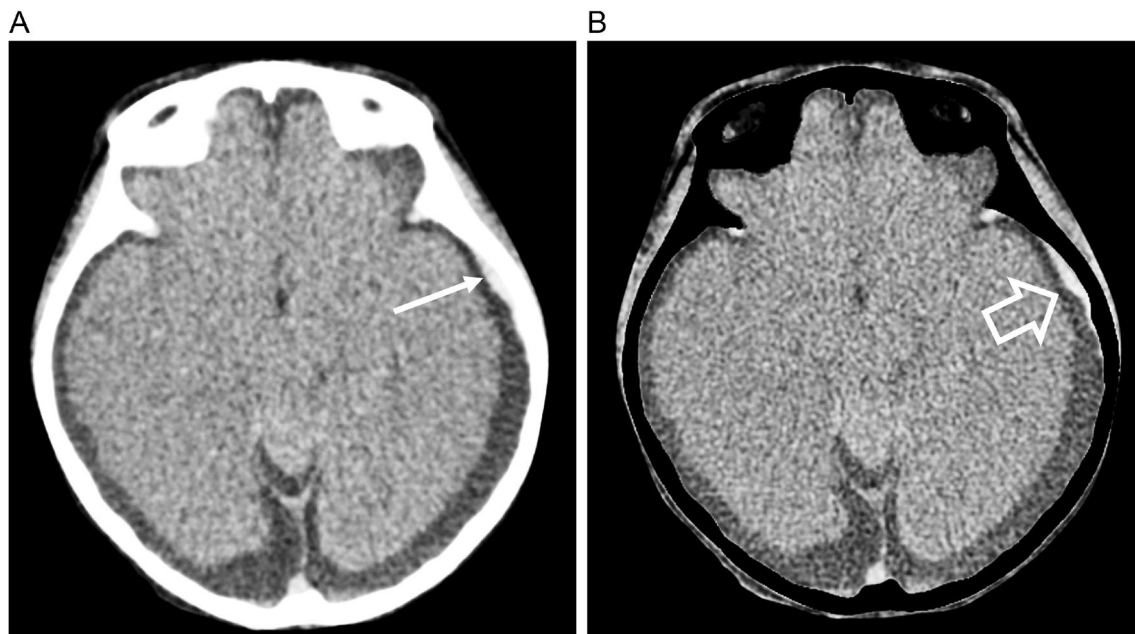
A 4-year-old girl who died following cardiac arrest. a A 3-mm axial image from a dual-energy computed tomography scan (dual source with tube voltage values of 80 and 140 kVp with a tin filter) shows prominent extra axial spaces, a stable finding for this patient, with a small extra axial blood collection on the left (*arrow*).
